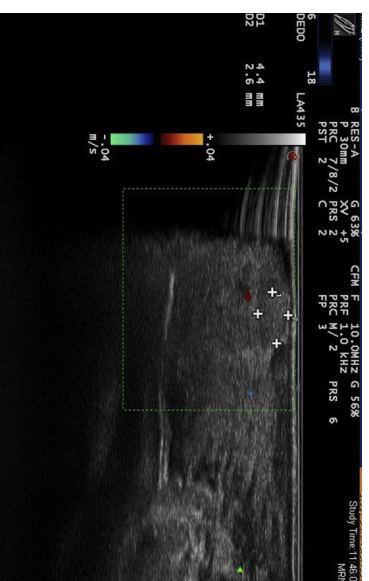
Ultrasound image of the full length of the lesion.
